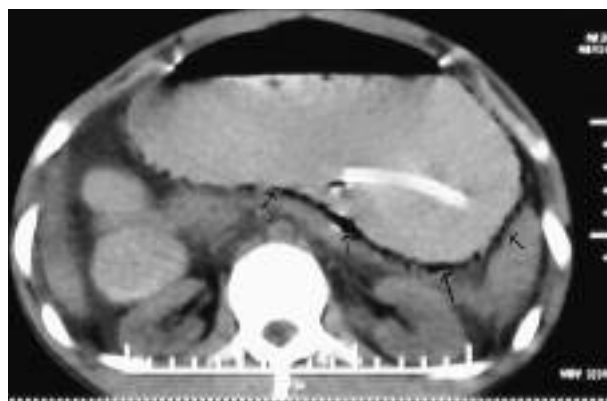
CT scan showing intramural gastric air (black arrows).
